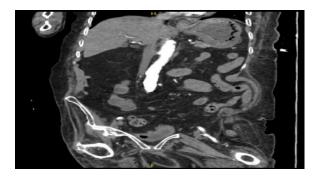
CT abdomen coronal view.
